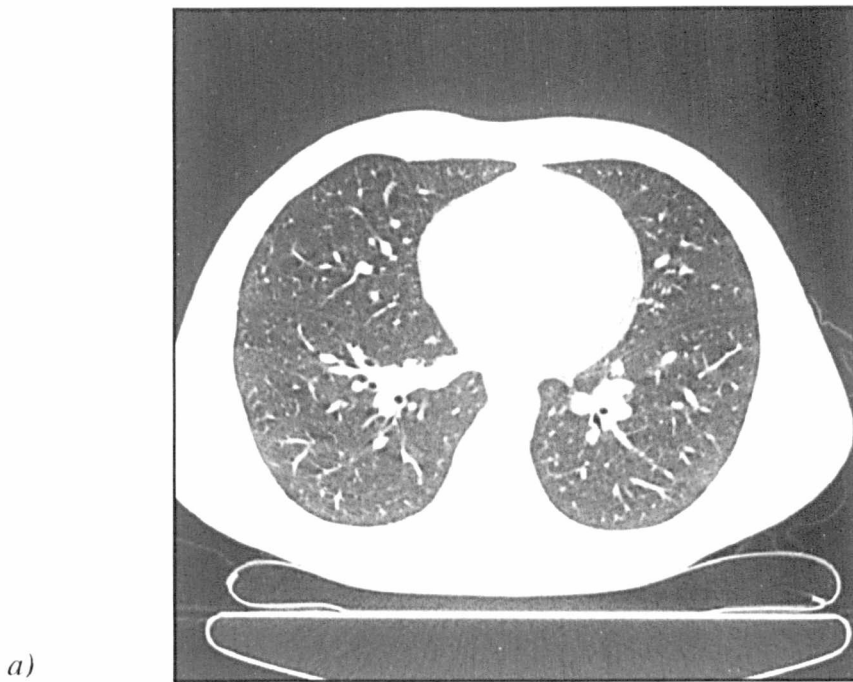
a) Example of CT scan of normal lungs with visible vertical density gradient (window settings: level = -800 H.U./ width = 1000 H.U.). Due to gravity, the posterior part of the lung appears denser than the anterior part. These density differences in the parenchyma are not related to small airways disease. b) Measure of the mean density of the parenchyma along horizontal lines, from anterior lungs to posterior lungs. A density increase can be observed, and modelled by a linear gradient. In this case, the slope of the regression is 0.46 H.U./mm.
